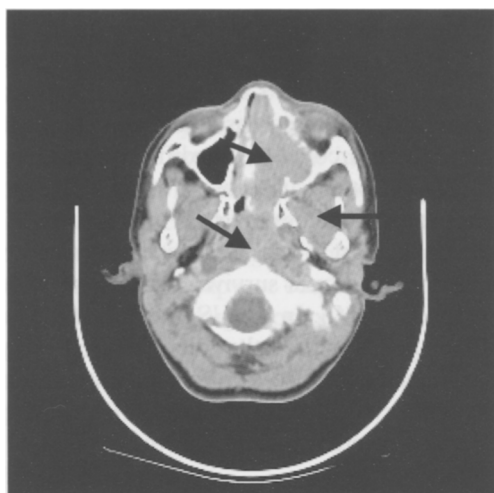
Para-meningeal alveolar rhabdomyosarcoma in an 8-year old boy with cervical nodal invasion. Initial CT scan shows massive infiltration of para-nasal sinuses.
